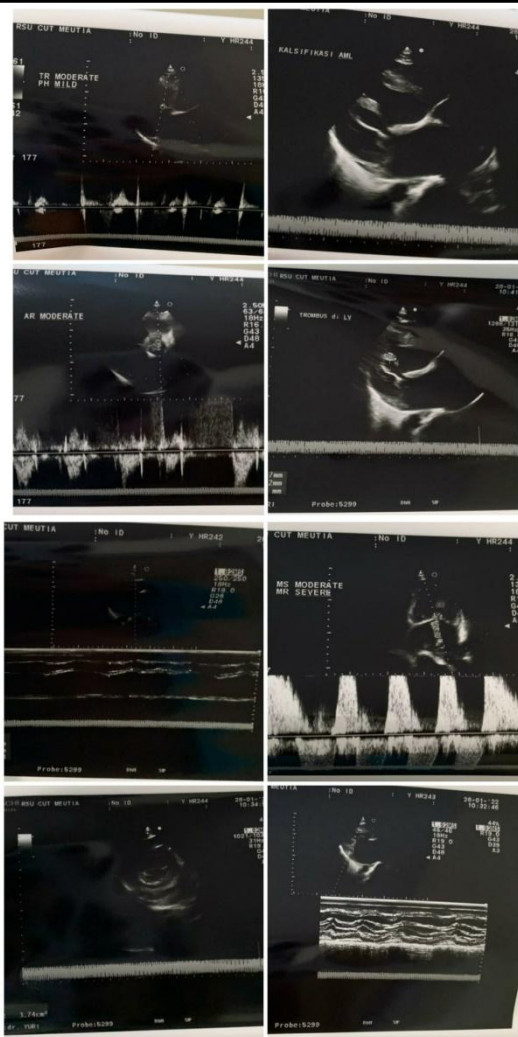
Transthoracic echocardiogram
